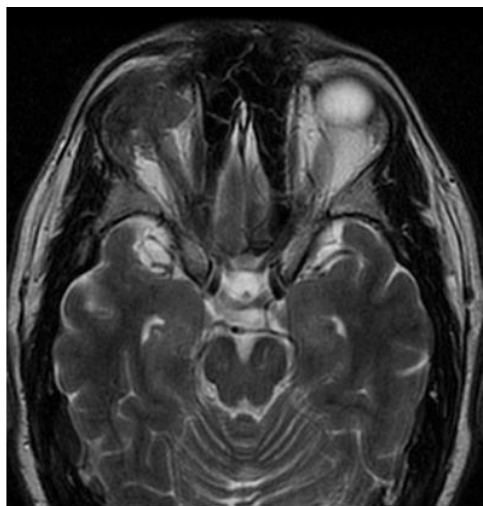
Magnetic resonance imaging (MRI) fragment of patient V., a 60-year-old man. In orbital lymphomas, oval-shaped tumors
